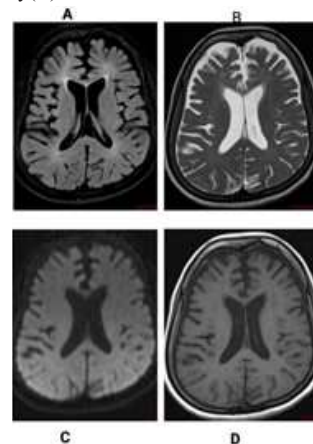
HIV encephalopathy -20 yr old female patient presented with cognitive decline on FLAIR axial image (A) and T2(B) showing hyperintensity along bilateral deep white matter and periventricular region, showing no diffusion restriction on DWI (C), and also appears iso to hypointense on T1 (D) with prominence of sulcal spaces due to marked cortical atrophy (age disproportionate)
